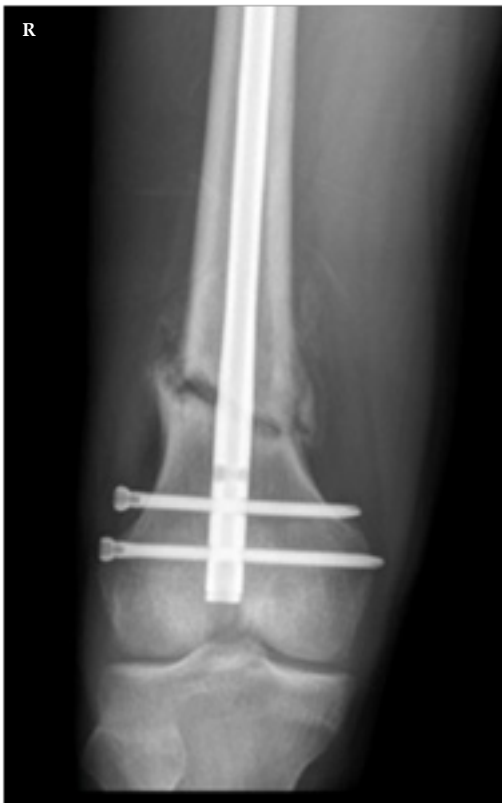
Post-op radiograph - Right, AP, post retrograde femoral intramedullary nailing.
